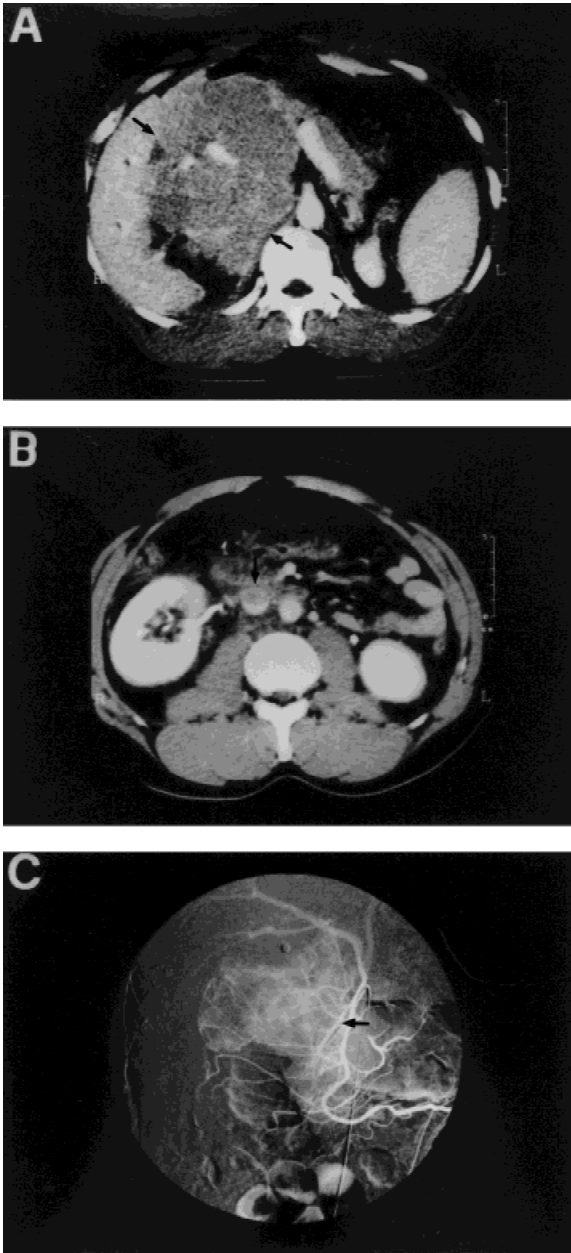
Computed tomographic scan revealed a huge retroperitoneal tumor (arrows) of soft tissue density with anterior displacement of pancreatic head (A) and inferior vena cava thrombosis (arrow) (B). The main feeding artery arose from the posterior pancreaticoduodenal artery (arrow) (C).
